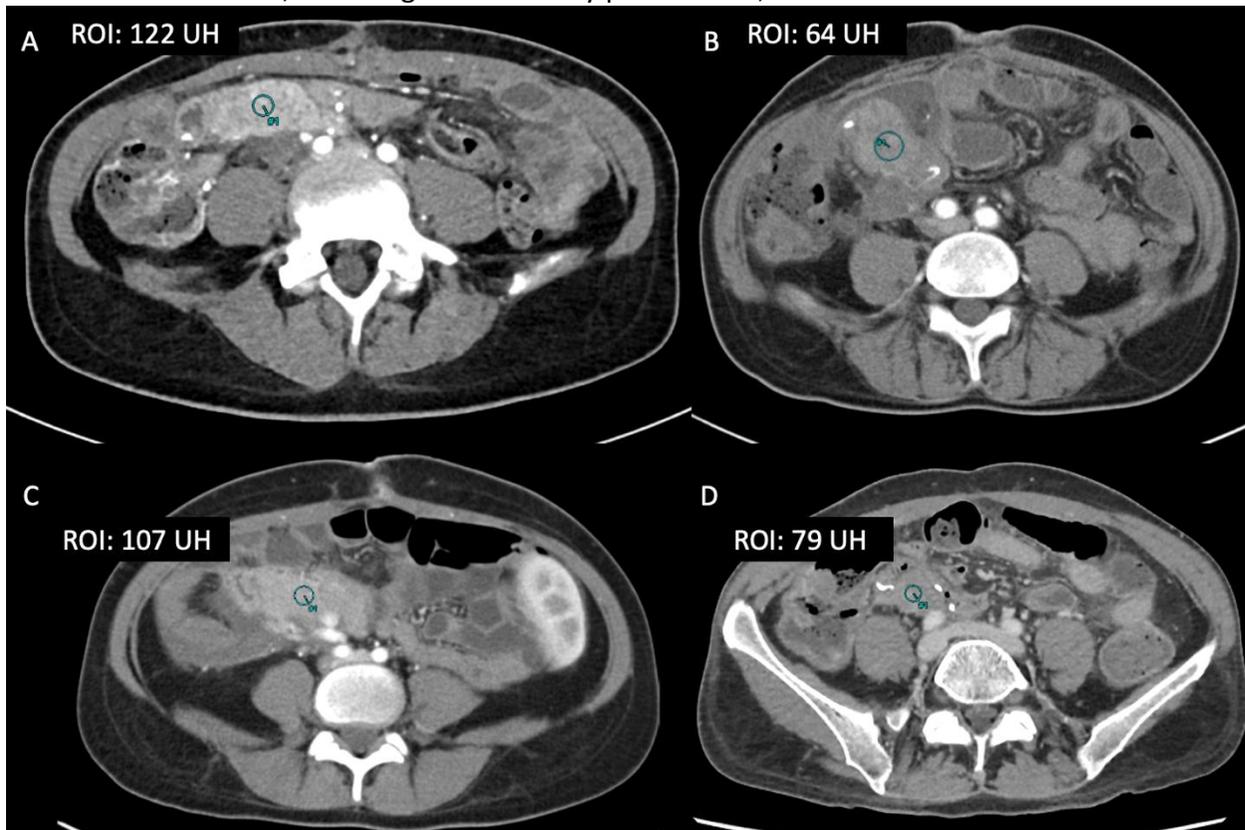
Contrast enhanced CT in four different patients after pancreatic transplantation. A region of interest (ROI) is drawn in the pancreas in the four patients. A. normal pancreatic parenchyma; B. Inflammatory pancreatitis; C. decreased parenchymal enhancement from venous thrombosis; D. decreased parenchymal enhancement from arterial thrombosis.
